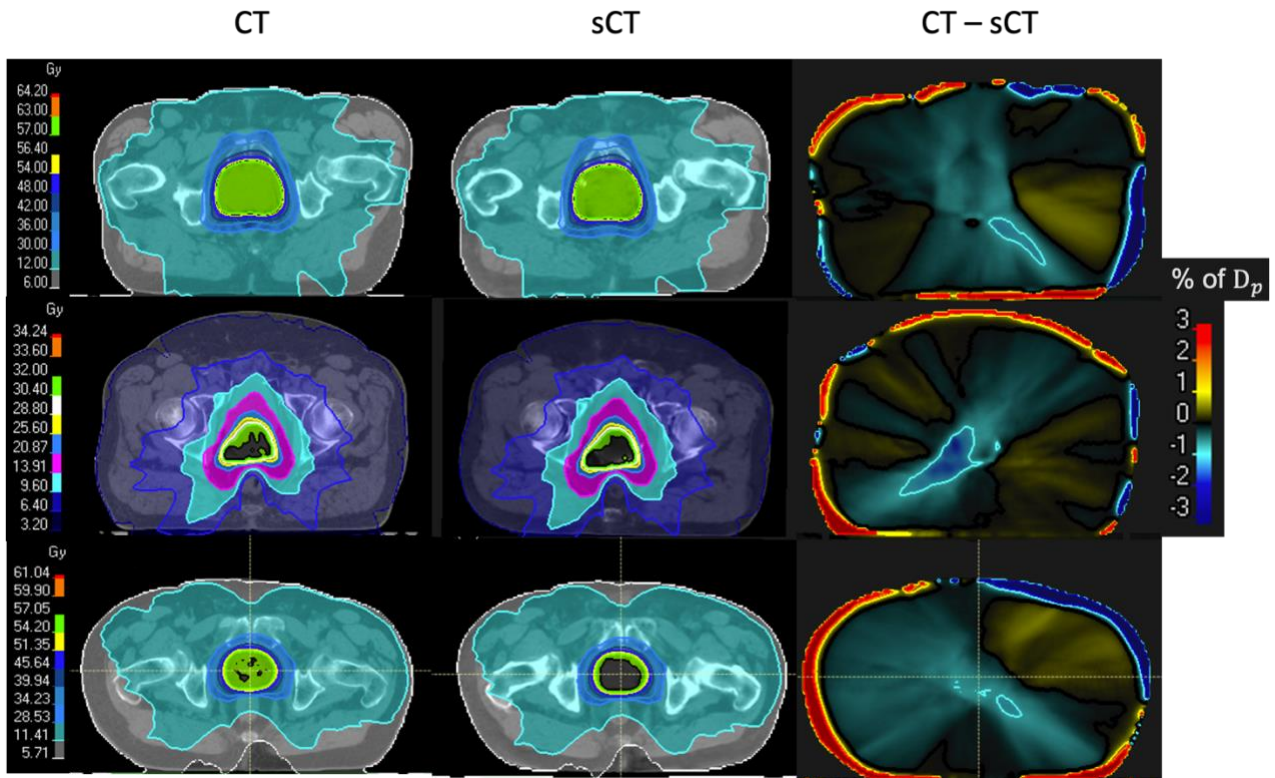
From left to right, doses calculated on CT and sCT and the relative dose difference (CT – sCT).
